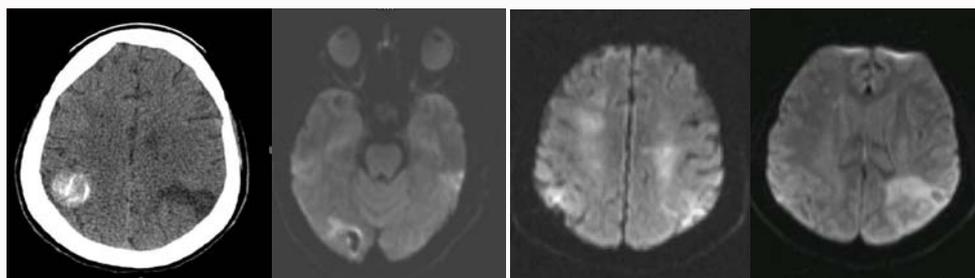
CT and MRI Brain (contrast) showing bilateral hyperintense signals with calcified meningioma.
